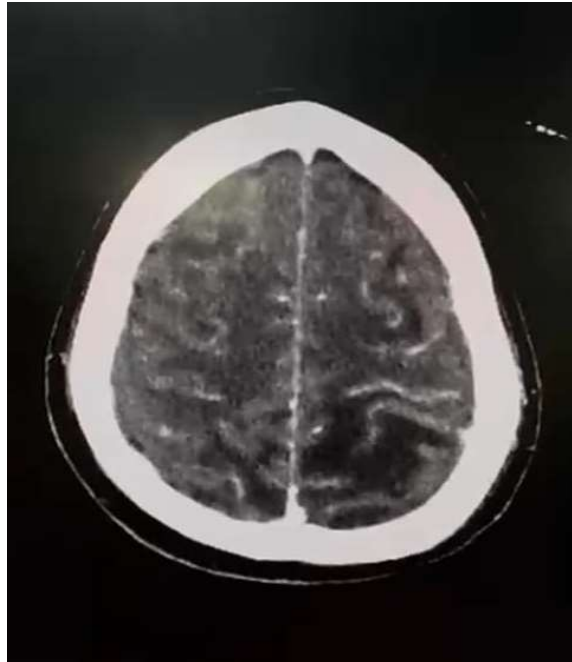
Axial Plain and Contrast CT Brain Image Showing Bilateral Cortical and Subcortical Fronto-Parietal Hypodensities with Edematous Changes Suggestive of Posterior Reversible Encephalopathy Syndrome (PRES) Secondary to Eclampsia
